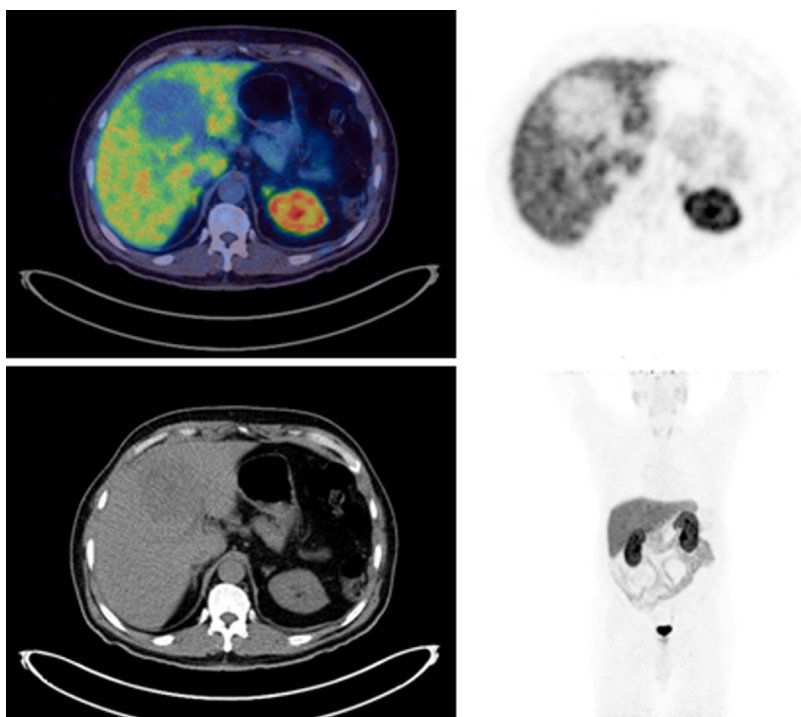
A 56-year-old man with new diagnosis of metastatic NET for staging. The ^{68}Ga -DOTATATE study demonstrates no abnormal uptake. In fact, the large liver metastasis is photopenic. Biopsy of this liver lesion revealed a high-grade neuroendocrine carcinoma with Ki-67 proliferative activity at 30%. Learning point: High-grade or poorly differentiated NETs often show negative finding on SSR imaging. Consider ^{18}F -FDG-PET/CT to more accurately stage these patients.
